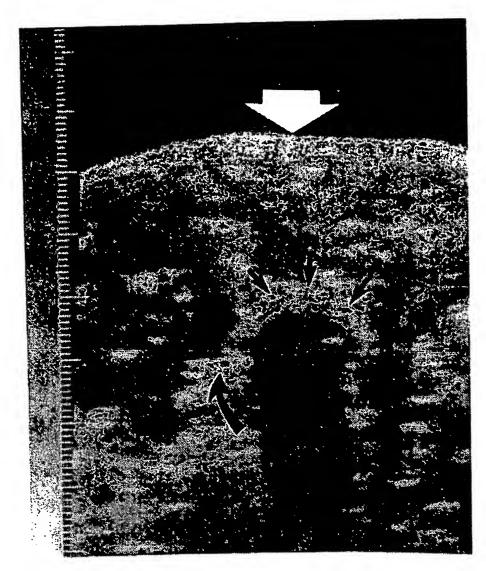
A typical ultrasound image of a frozen lesion in the liver. The white arrow indicates the outer surface of the liver where the ultrasound transducer was placed. The black arrows show the margin of the hemispherical frozen lesion as seen with conventional ultrasound.
